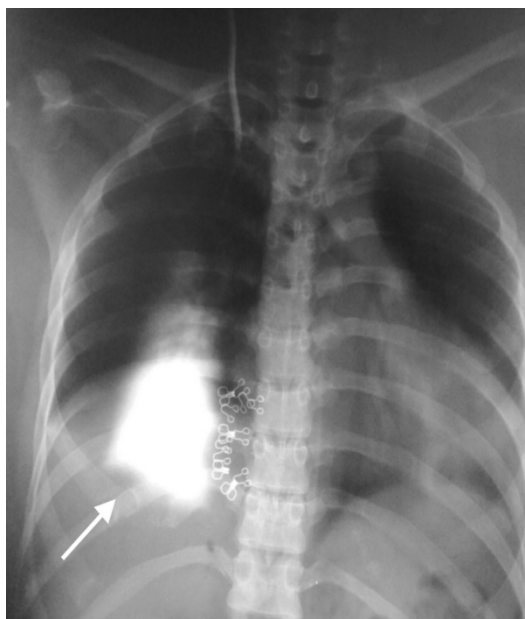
Chest X-ray obtained after dye injection shows dye distribution to the pleural cavity (arrow)
